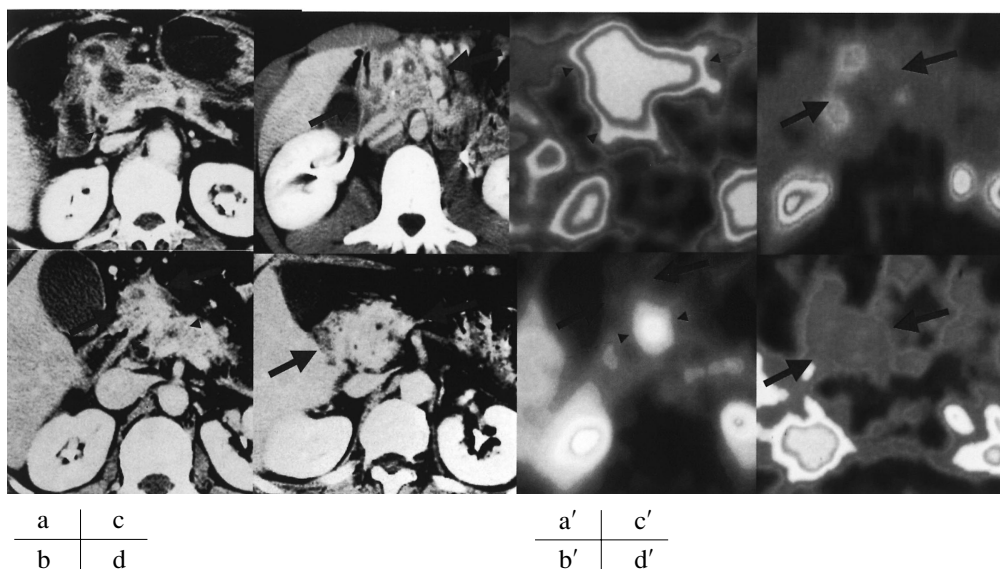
Differential diagnosis of pancreatic cancer from mass-forming pancreatitis. Heterogeneous mass lesions in the pancreatic head are shown in the CT images (a–d) and PET images (a'–e'), corresponding to each other. Figure a shows a pancreatic cancer case, which was diagnosed using CT as pancreatic cancer with pseudo-cystic change. However, FDG PET revealed a high uptake throughout the lesion (a'). Figure b shows a pancreatic cancer case, which was first diagnosed as acute pancreatitis with pseudo-cysts using a CT scan. However, FDG PET detected a pancreatic cancer in the pancreatic head without any uptake in the cystic portion (b'). In both cases, PET findings were confirmed by operation. Figures c–d show typical mass-forming pancreatitis cases without any focal uptake in the lesions by FDG PET.
